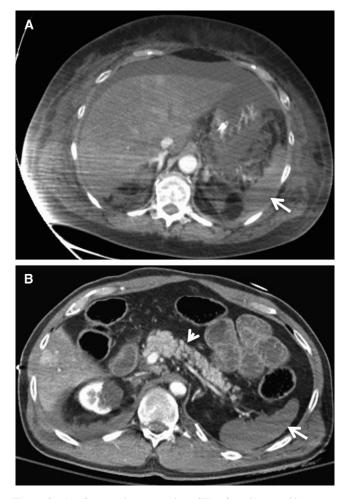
(A) Computed tomography (CT) of a 51-year-old woman, demonstrating several features of hypovolemic shock: dense right adrenal gland, liver and splenic hypoperfusion (arrow), and moderate free fluid. (B) CT of a 46-year-old man, displaying various findings indicative of hypovolemic shock complex: left adrenal gland hyperenhancement, splenic hypoperfusion (arrow), small bowel wall thickening and enhancement, as well as abnormal enhancement of the pancreas (arrowhead).
